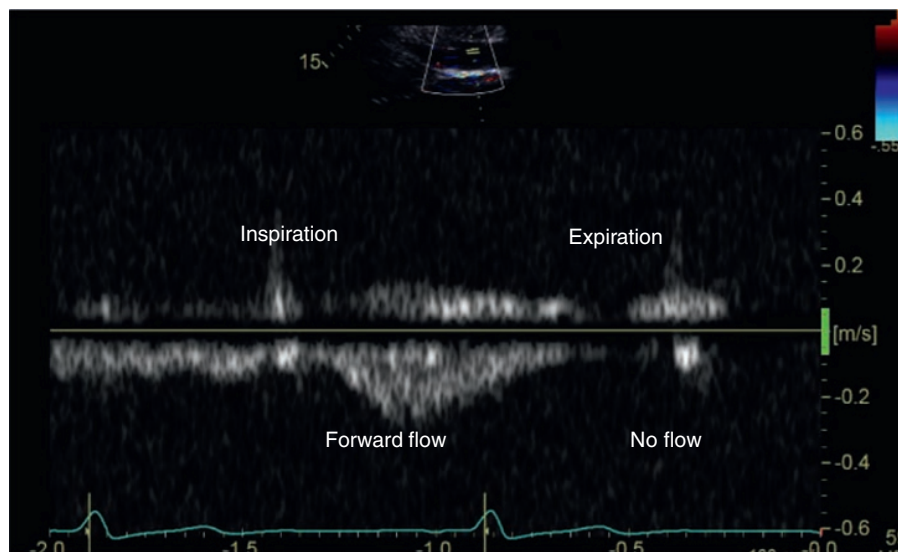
Flow in the hepatic vein–inferior vena cava (IVC) junction. The increase in flow during inspiration and almost absent flow during expiration can be demonstrated on the pulsed-wave Doppler tracing. The presence of respiratory variation in the hepatic and IVC flows suggests the presence of an unobstructed connection.
